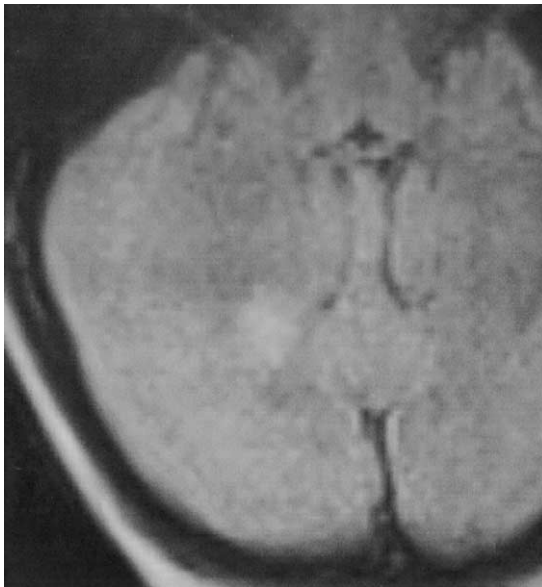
Axial T2-weighted MRI of unidentified bright object in the cerebellar white matter.
